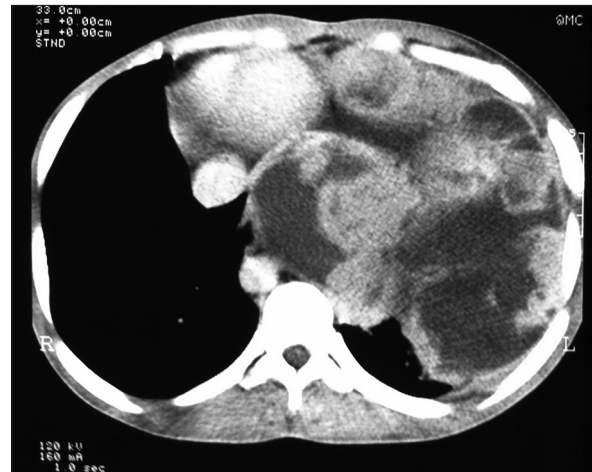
Contrast-enhanced computed tomography chest showing heterogenous mass in the left hemithorax
